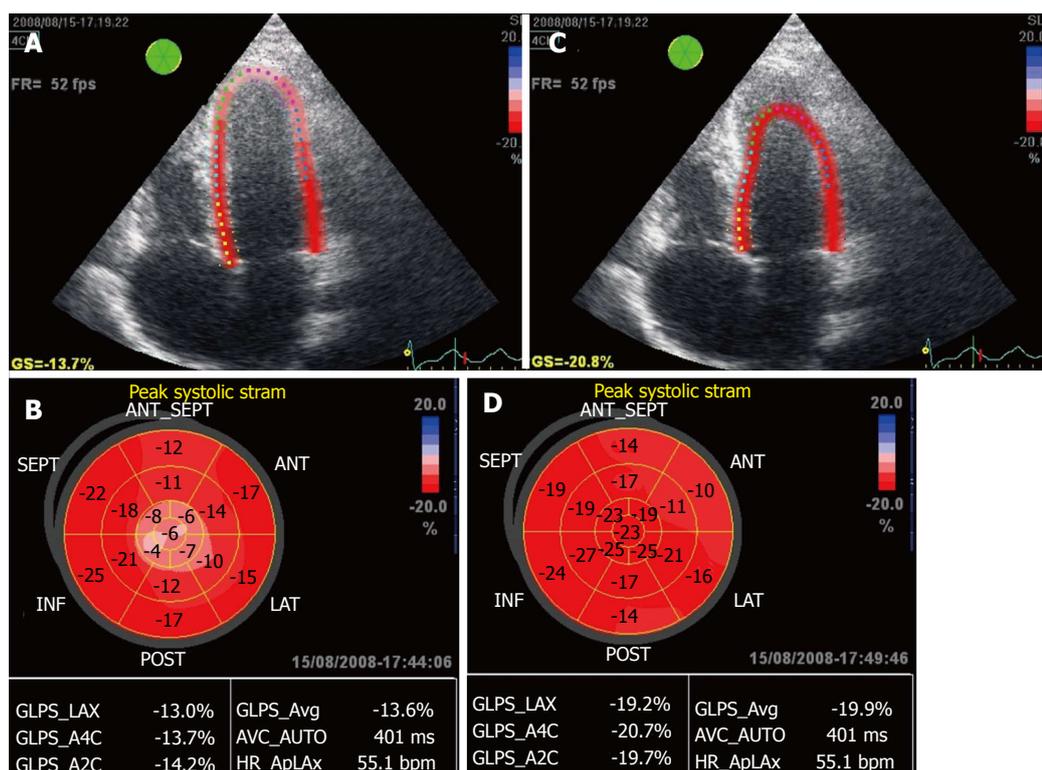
Apical 4-chamber view of a patient with apical hypertrophic cardiomyopathy. A: Midwall parametric image; B: Midwall bull's eye with a mean global longitudinal peak systolic strain (GLPS_Avg) of -13.6%; C: Endocardial parametric image; D: Endocardial bull's eye with a GLPS_Avg of -19.9%. Red: Normal strain; Pink: Reduced strain; Light pink: Severely reduced strain.
